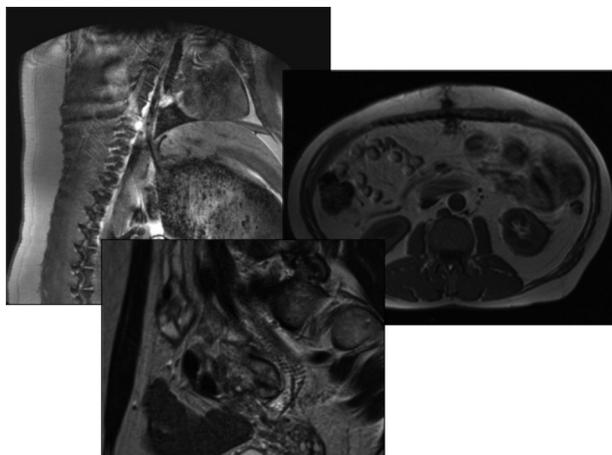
Different visible mesh structures in MRI.
